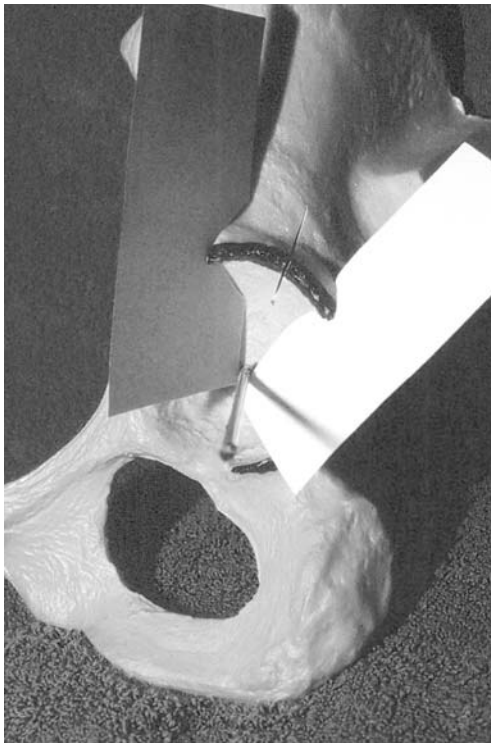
The sectional plane is tilted forward and backward, respectively. The tilting causes deflection of the ultrasound beam, with poor reflection of the labrum, which is inadequately seen
